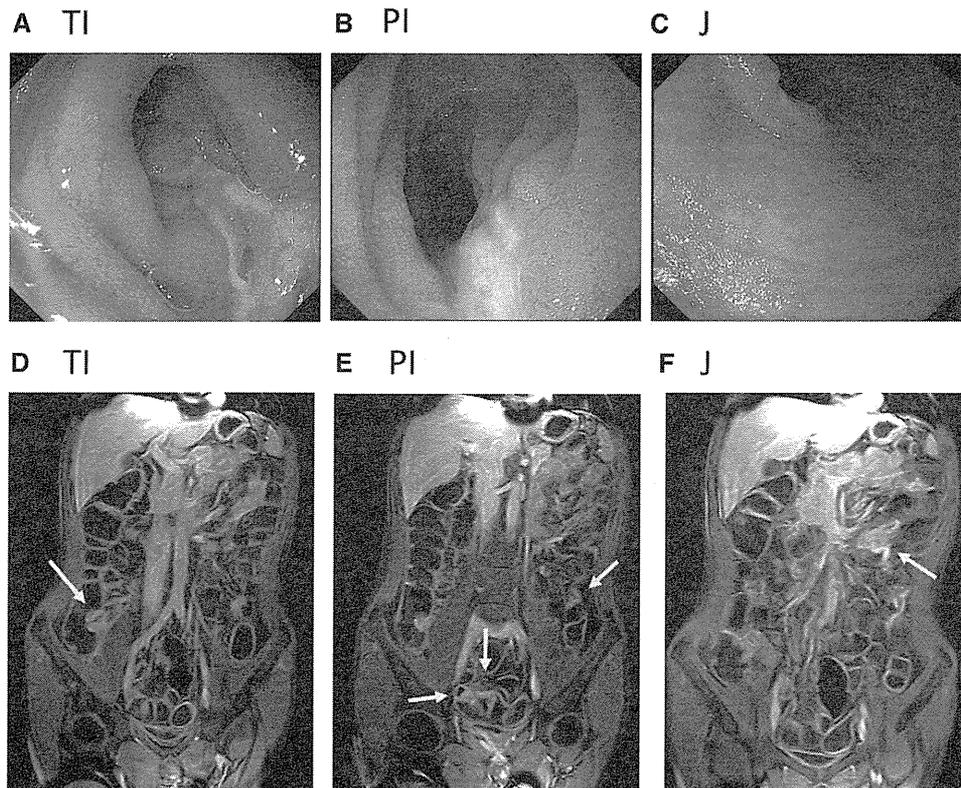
An example of small intestinal lesions. Enteroscopy detected a longitudinal ulcer both in the terminal ileum (TI; A) and proximal ileum (PI; B) and detected a small ulcer in the jejunum (J; C). The SES-CD was 7 in TI, 6 in PI, and 5 in J. MR enterocolonography with 3D T1-weighted contrast-enhanced sequence also detected active lesions as wall thickness and contrast enhancement both in TI and PI (D-F; yellow arrows). The MaRIA score was 29.4 in TI, 17.2 in PI, and 10.8 in J.
